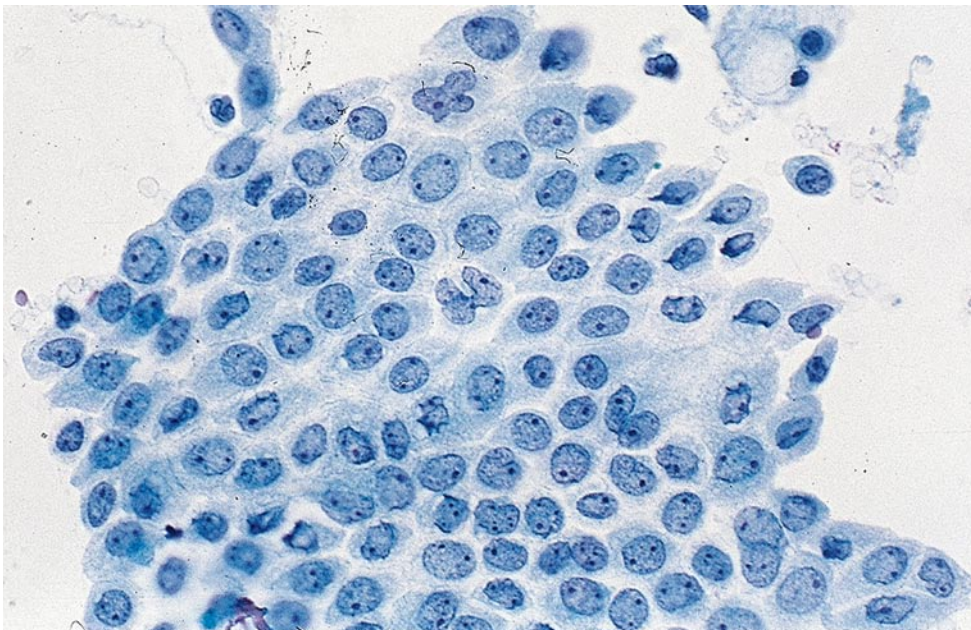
Mesothelial cells (fine-needle aspiration [FNA]). Benign mesothelial cells are occasionally seen in transthoracic fine-needle aspirates. They are arranged in flat, cohesive sheets. The cells have round or oval nuclei, small nucleoli, and a moderate amount of cytoplasm, and space between cells—windows—can be appreciated.
